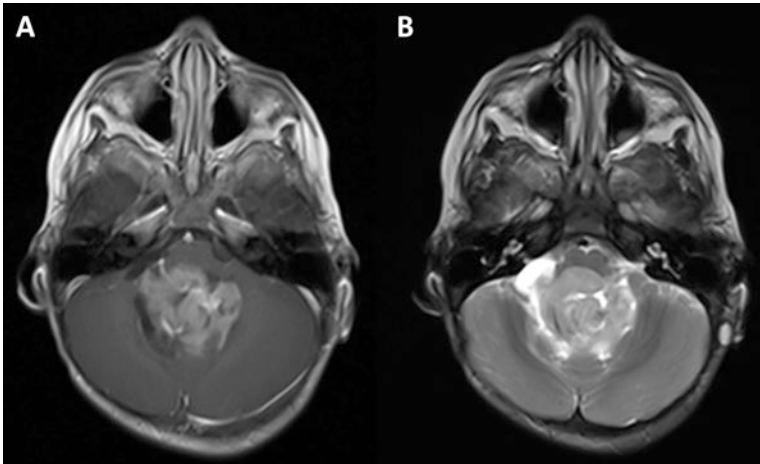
Fifteen month male with ependymoma with cystic and solid components localized to the fourth ventricle measuring 3.9×3.4 cm. (a) T1 post-gadolinium image. (b) T2-weighted image
